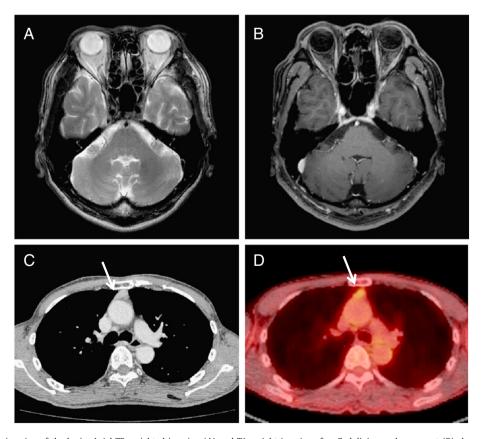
Magnetic resonance imaging of the brain. Axial T2-weighted imaging (A) and T1-weight imaging after Gadolinium enhancement (B) show no abnormal lesion on the cerebellum or brainstem. Axial computed tomography of the chest shows an anterior mediastinal tumor (C, arrow). 18F fluoro-2-deoxy-glucose-positron emission tomography scan shows hypermetabolic focus on the anterior mediastinal tumor (D, arrow).
